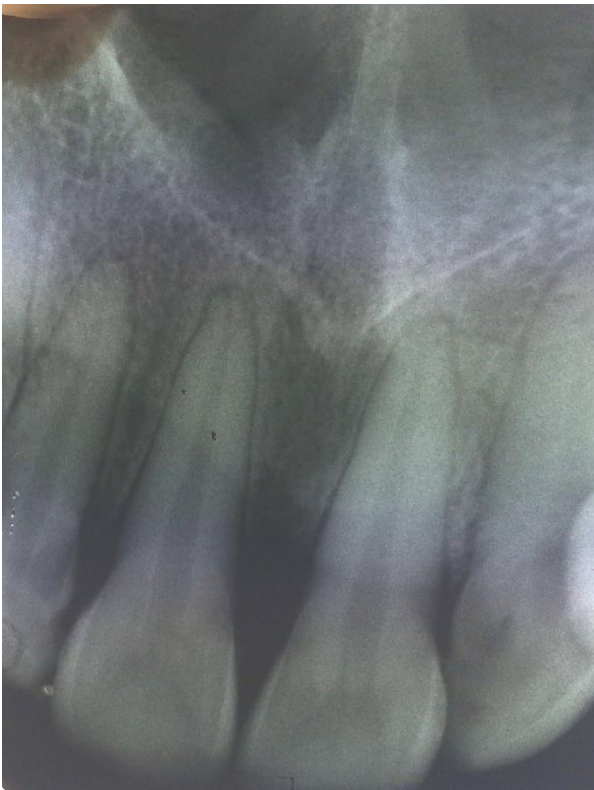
Intra oral periapical radiograph showing bone loss
